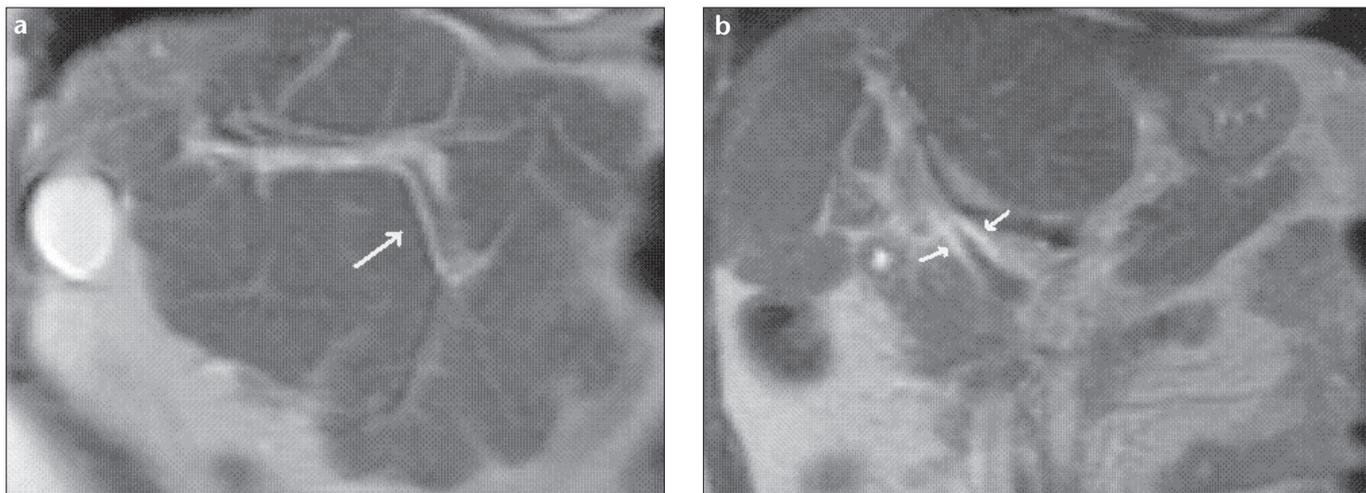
a, b. Periportal edema and contour lobulation. Coronal T2-weighted MR images show increased band shaped intensity compatible with edema, which is in the vicinity of the portal vein (arrows), and evident lobulation on the liver surface.
